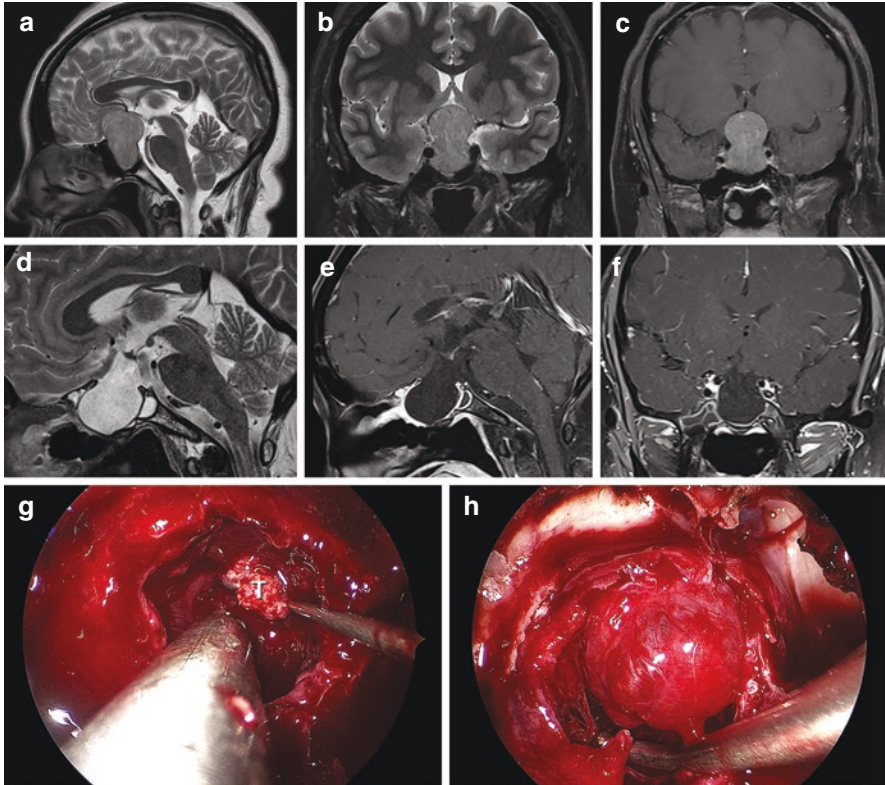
Plurihormonal PIT-1-positive adenoma. Pre- (a–c) and postoperative (d–f) MR images. Intraoperative views demonstrating the tumor gross appearance (g) and its complete resection with full descent of the cistern (h)
